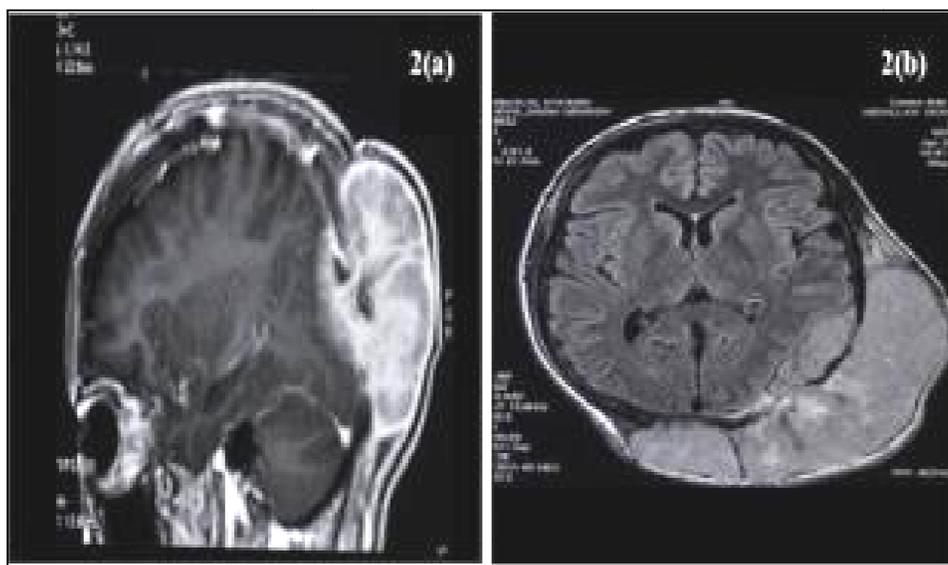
MRI (axial) T2-weighted (2a), sagittal T1- weighted (2b) after gadolinium: Parieto occipital left mass involving the scalp with extra dural and extra cranial extension
